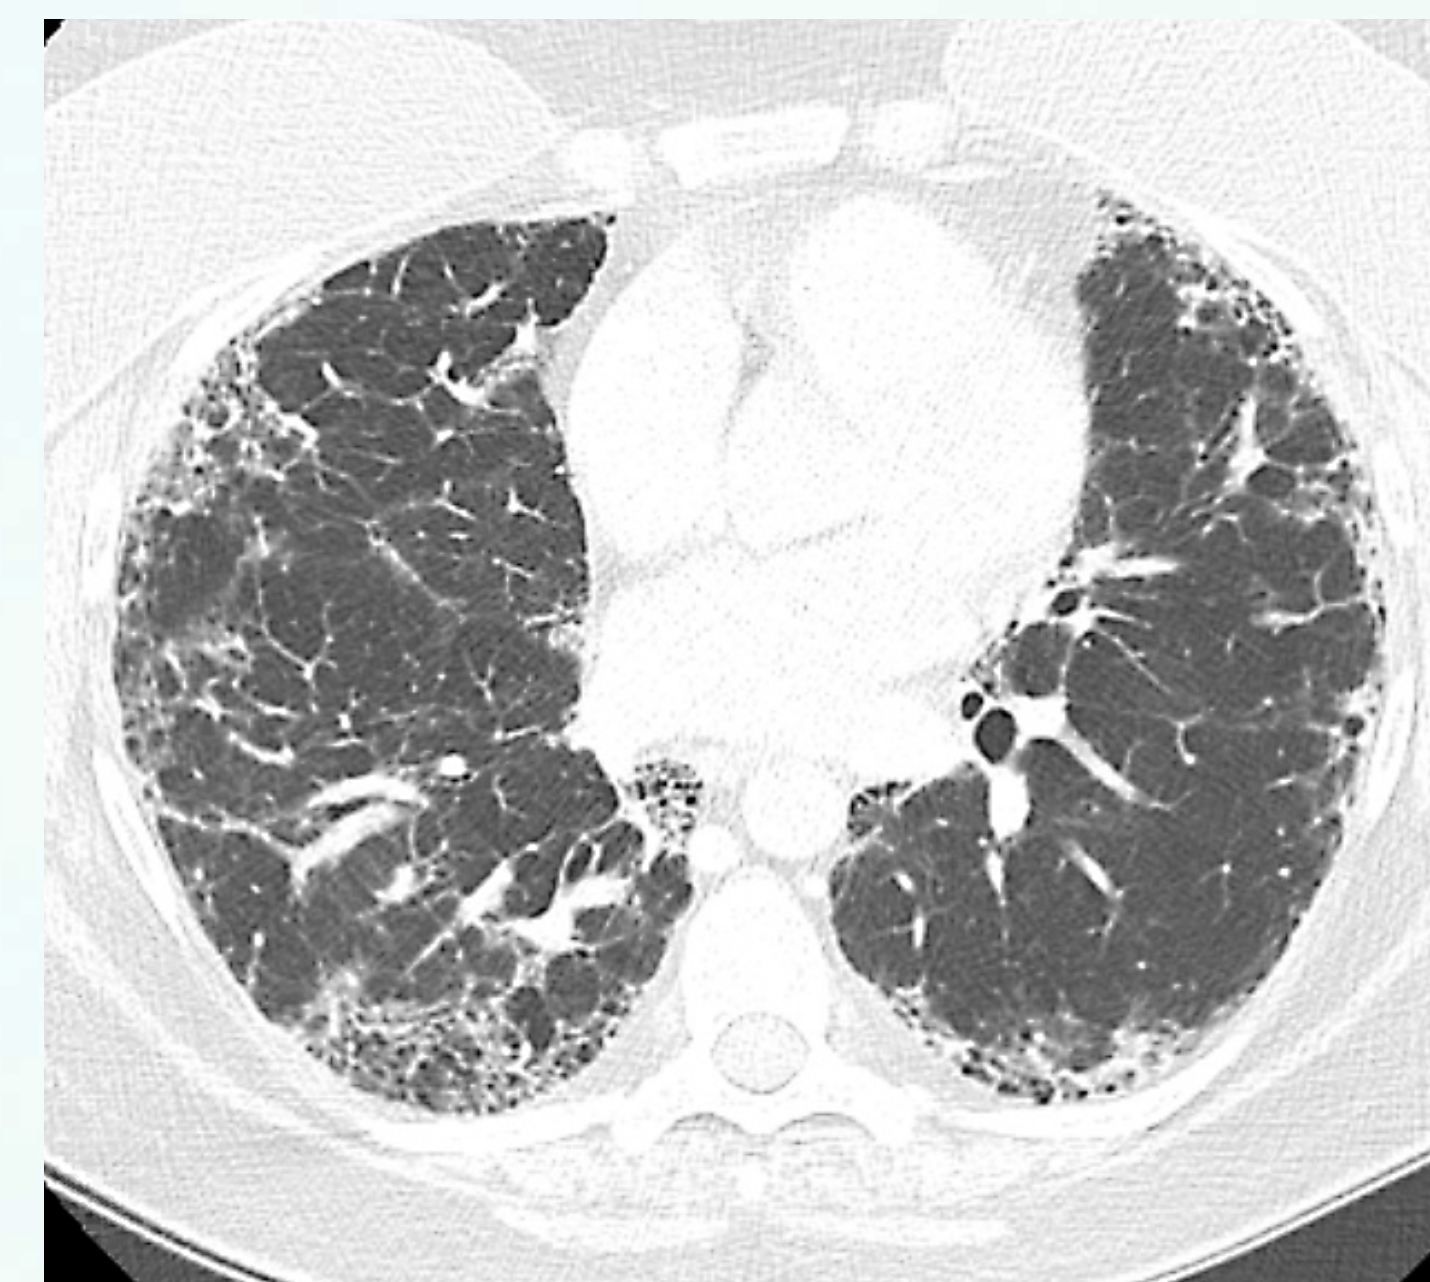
CT chest in the transverse view showing interlobular septal thickening, subpleural peripheral honeycombing and ground-glass opacities.
